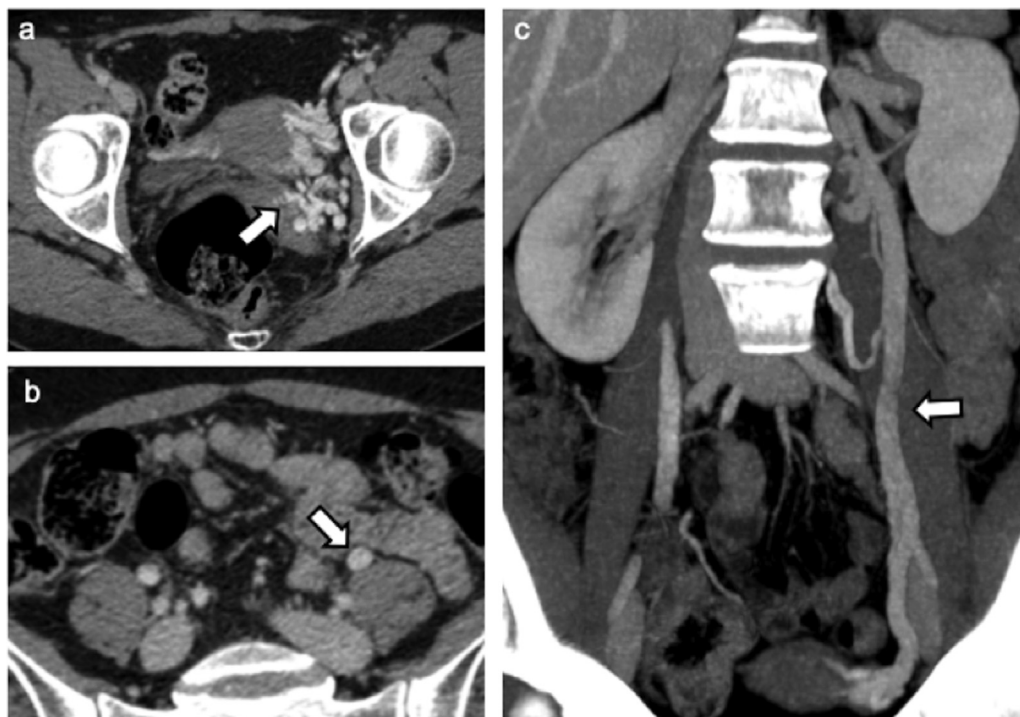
CT imaging shows a left ovarian vein Grade II reflux: (a) left parauterine veins dilation (arrow); (b) left ovarian vein dilation (arrow); (c) MIP reconstruction showing left ovarian vein dilation (arrow).
